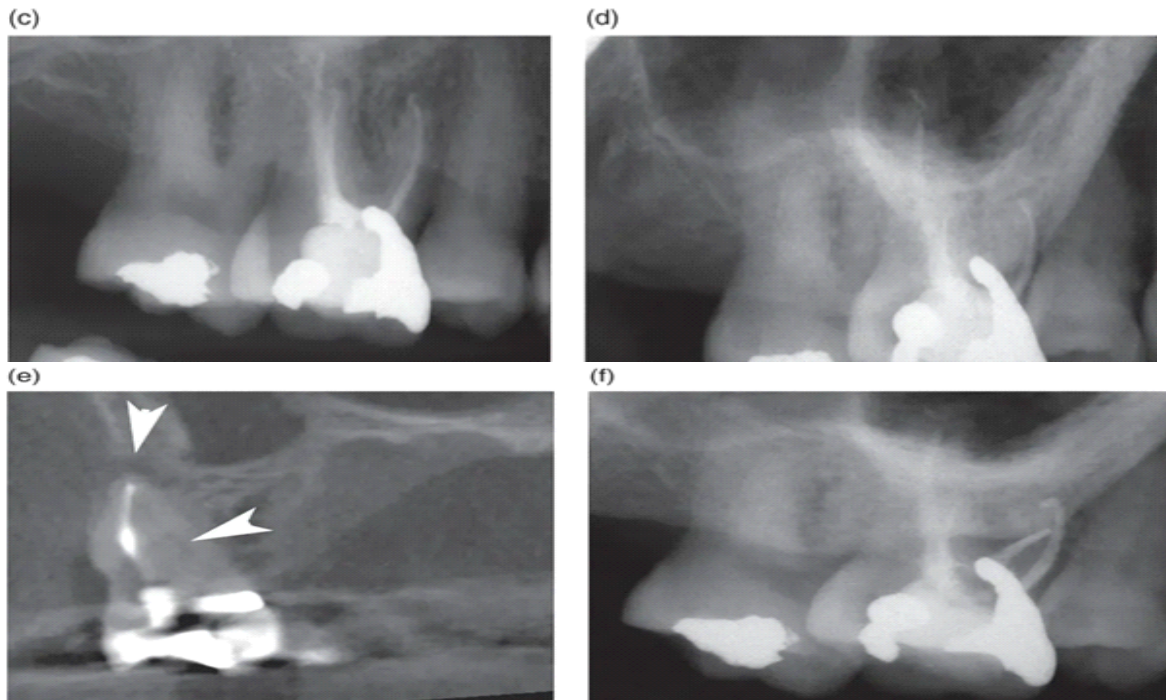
(a) Traditional radiograph; (b) cone beam computed tomography (CBCT) radiograph of maxillary left first molar (in a) with previous endodontic treatment and a separated instrument in the mesio-buccal (MB) canal; note that the CBCT image showed a large periapical lesion that the periapical radiograph did not show; root end surgery confirmed that there was a thick cortical plate of bone and a lesion present in the medullary bone; (c) and (d) show two angles using periapical radiography in a different case that suggest a missed MB2 canal and a periapical lesion; (e) CBCT confirms that a missed canal and a lesion existed and shows their location and extent (arrows); (f) completed retreatment of MB1 and MB2.
